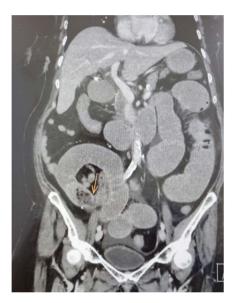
CT abdomen Single coronal plane showed foreign body in the ileum cause small bowel obstruction.
